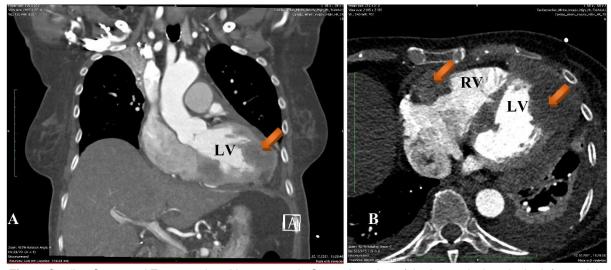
Cardiac Computed Tomography with contrast. A. Coronal section of the heart– lesions in the left ventricle (*arrow*). B. Axial section – metastasis in both parts of the heart (*arrows*).
